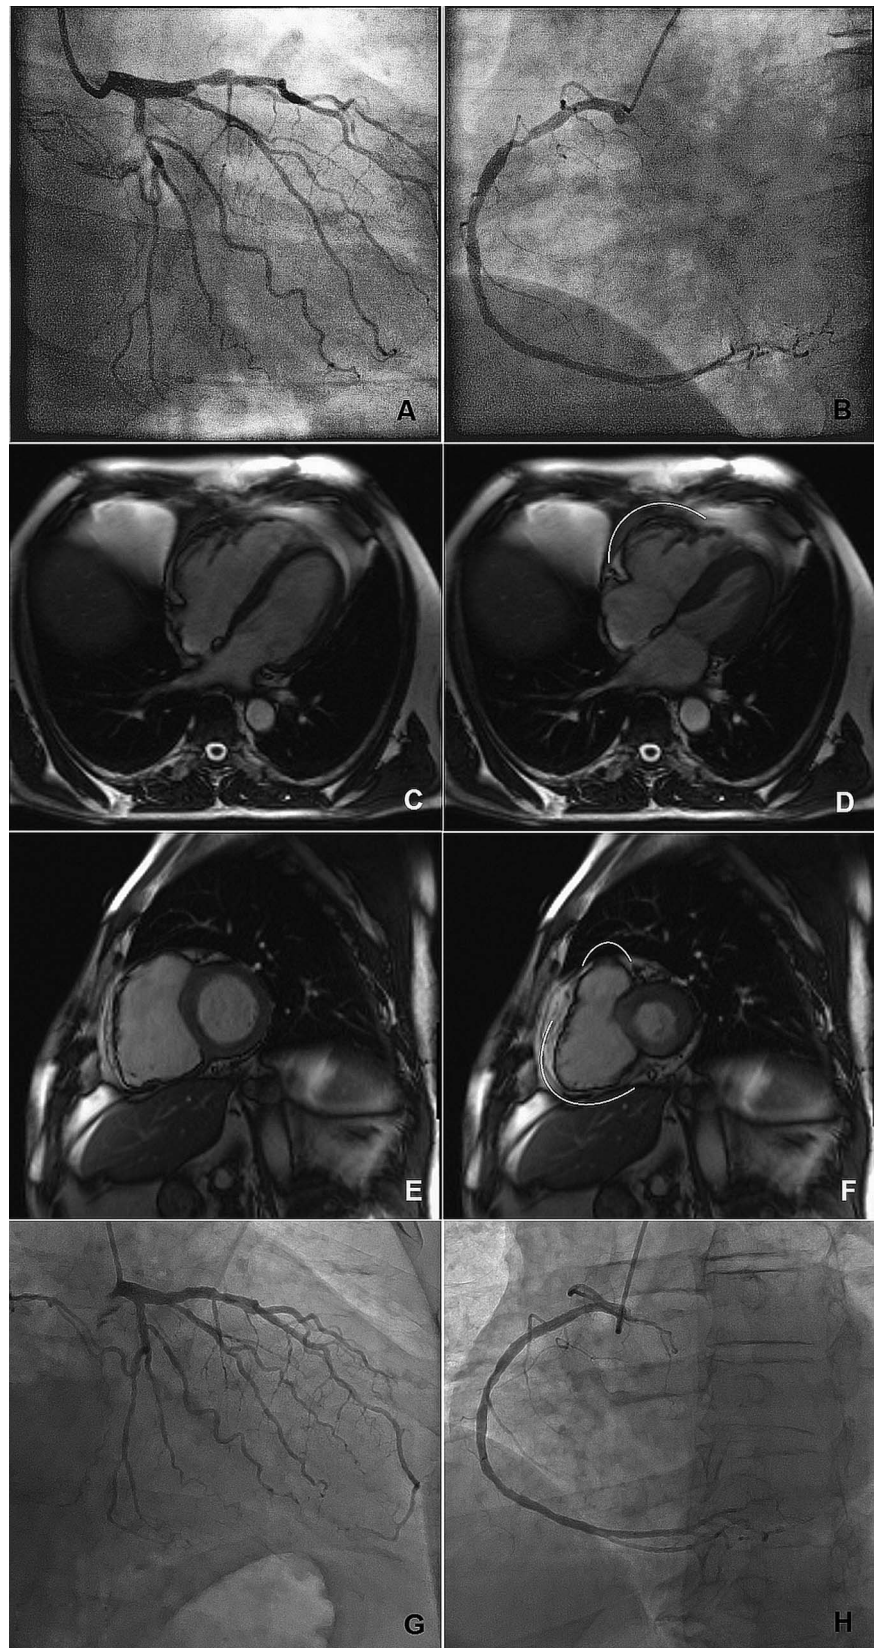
(A) Left coronary artery before stenting. (B) Right coronary artery before stenting. (C) Cardiac MRI in diastole, four-chamber view. (D) Cardiac MRI in systole, four-chamber view, showing large right ventricular (RV) basal lateral aneurism (white curve). (E) Cardiac MRI in diastole, two-chamber view. (F) Cardiac MRI in systole, two-chamber view, showing large aneurism on the RV acute margin and a smaller one in the RV outflow tract (white curves). (G) Left coronary artery 3 years after stenting; (H) right coronary artery 3 years after stenting.
